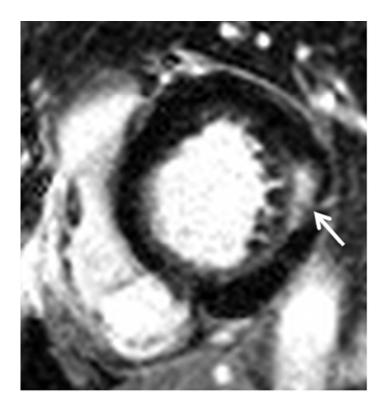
(a): Cardiovascular magnetic resonance image of the left ventricle in short axis demonstrating late gadolinium enhancement in the basal inferolateral wall (see arrow).
